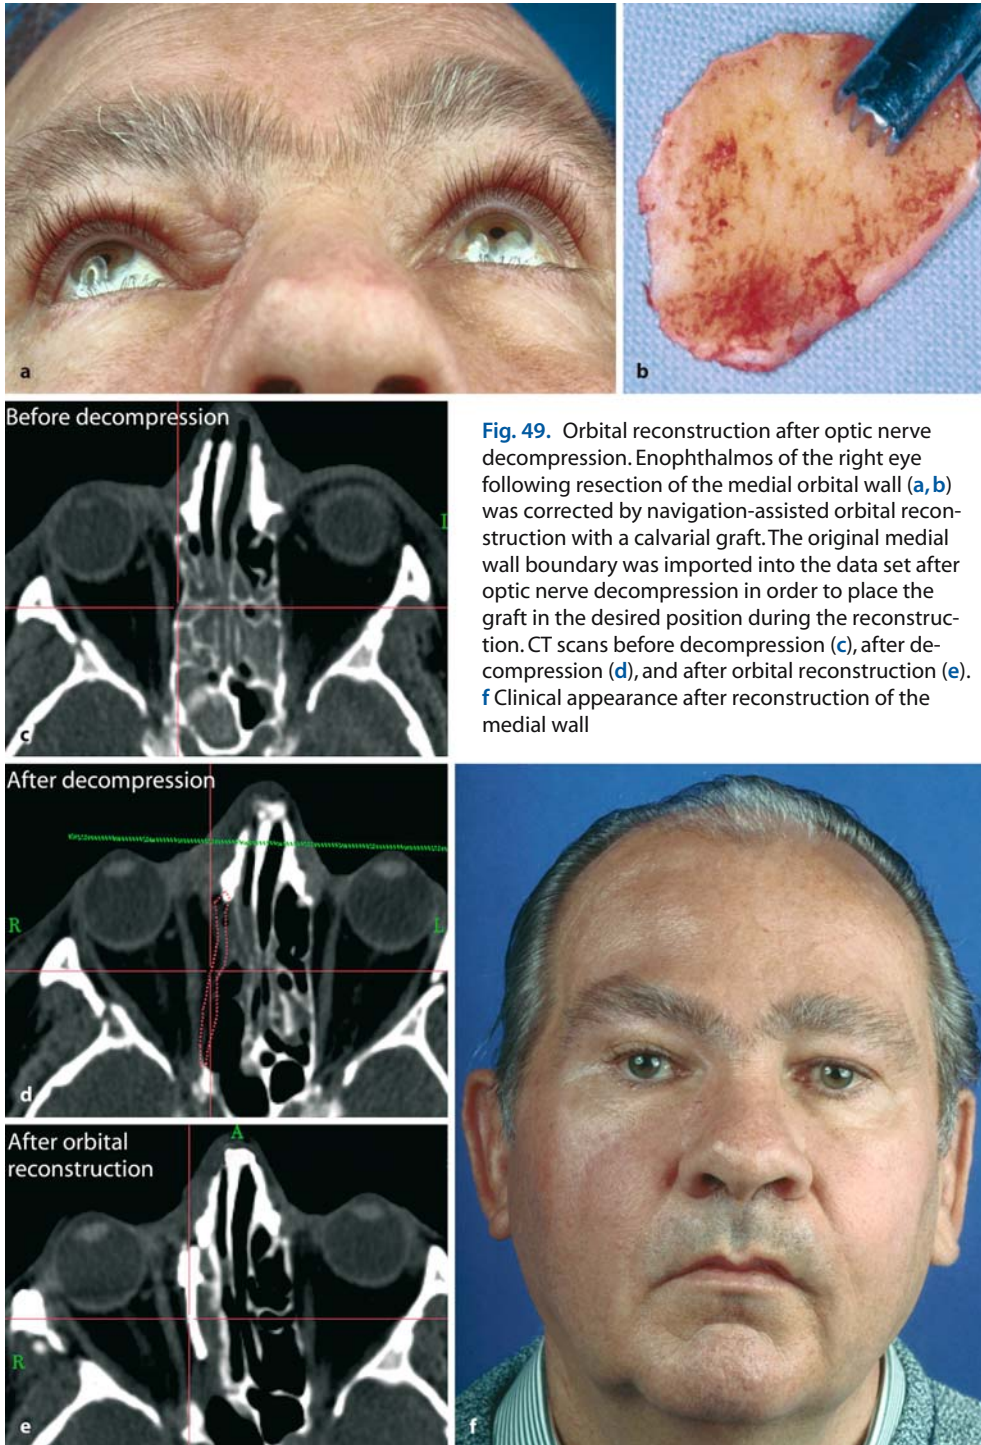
Orbital reconstruction after optic nerve decompression. Enophthalmos of the right eye following resection of the medial orbital wall (a, b) was corrected by navigation-assisted orbital reconstruction with a calvarial graft. The original medial wall boundary was imported into the data set after optic nerve decompression in order to place the graft in the desired position during the reconstruction. CT scans before decompression (c), after decompression (d), and after orbital reconstruction (e). f Clinical appearance after reconstruction of the medial wall
